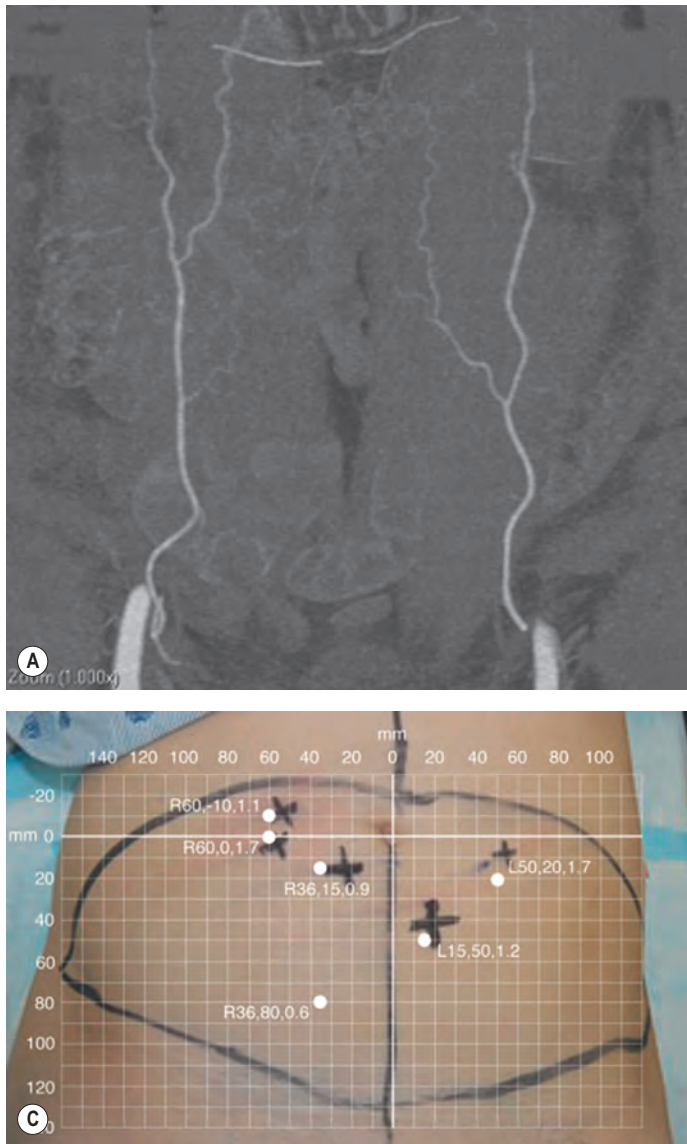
Use of computed tomography angiography (CTA) in the planning of deep inferior epigastric artery perforator flaps. (A) Axial view of abdomen in patient preoperatively before deep inferior epigastric artery flap reconstruction of the breast. (B) Using CTA to plan surgery. Markings show perforators detected with handheld Doppler. (C) Grid overlay with white dots reflects radiologist's description of cutaneous perforators based on CTA using coordinates: R/L, distance from midline in millimeters, distance inferior to umbilicus, size of perforator in millimeters. (From Al-Dhamin A, Berry R, Prasad MA, et al. Coding system for computed tomographic angiography of inferior epigastric artery perforators in DIEAP flaps. *Plast Reconstr Surg.* 2012;129:387e–388e.)
